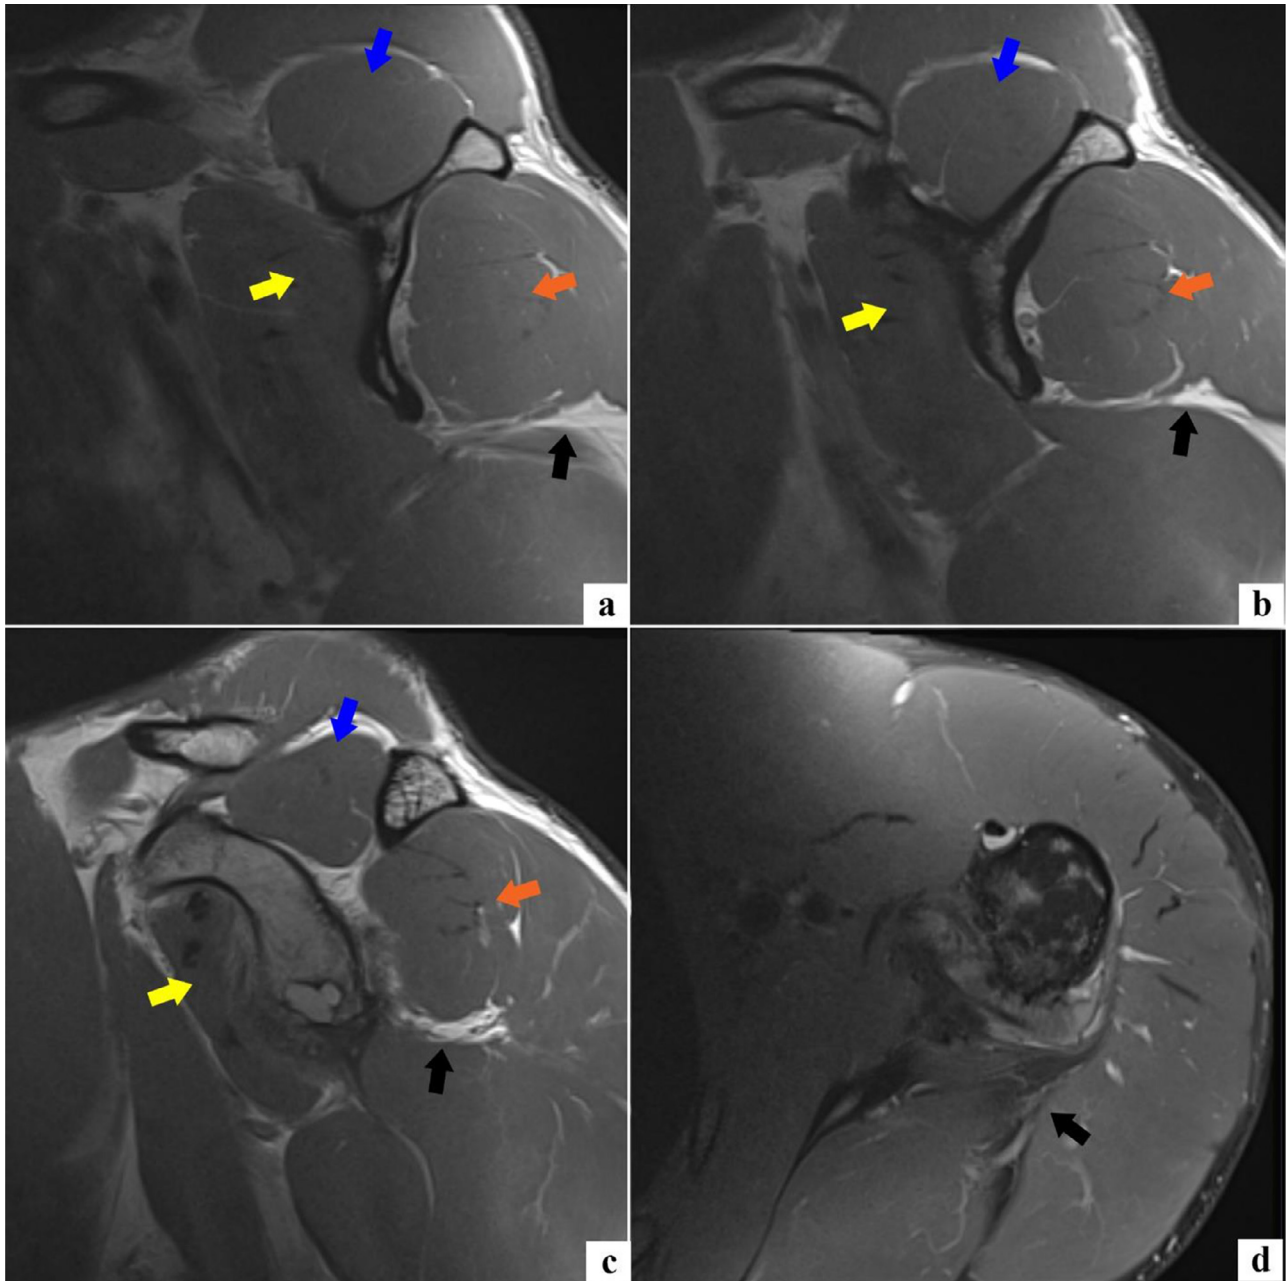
Sagittal T1 MRI of the left shoulder at the level of the scapula body (A) with 5mm cuts lateral (B-C) through the scapula body demonstrates marked isolated atrophy of the teres minor muscle (black circle). The infraspinatus (orange arrow), supraspinatus (blue arrow) and subscapularis muscles (yellow arrow) demonstrate normal muscle bulk. An axial T1 fat-saturated image at the level of the inferior aspect of the glenoid and mid-scapular body (D) demonstrates marked fatty atrophy of the teres minor muscle (black arrow). This appears hypointense since the axial sequence was fat-saturated.
